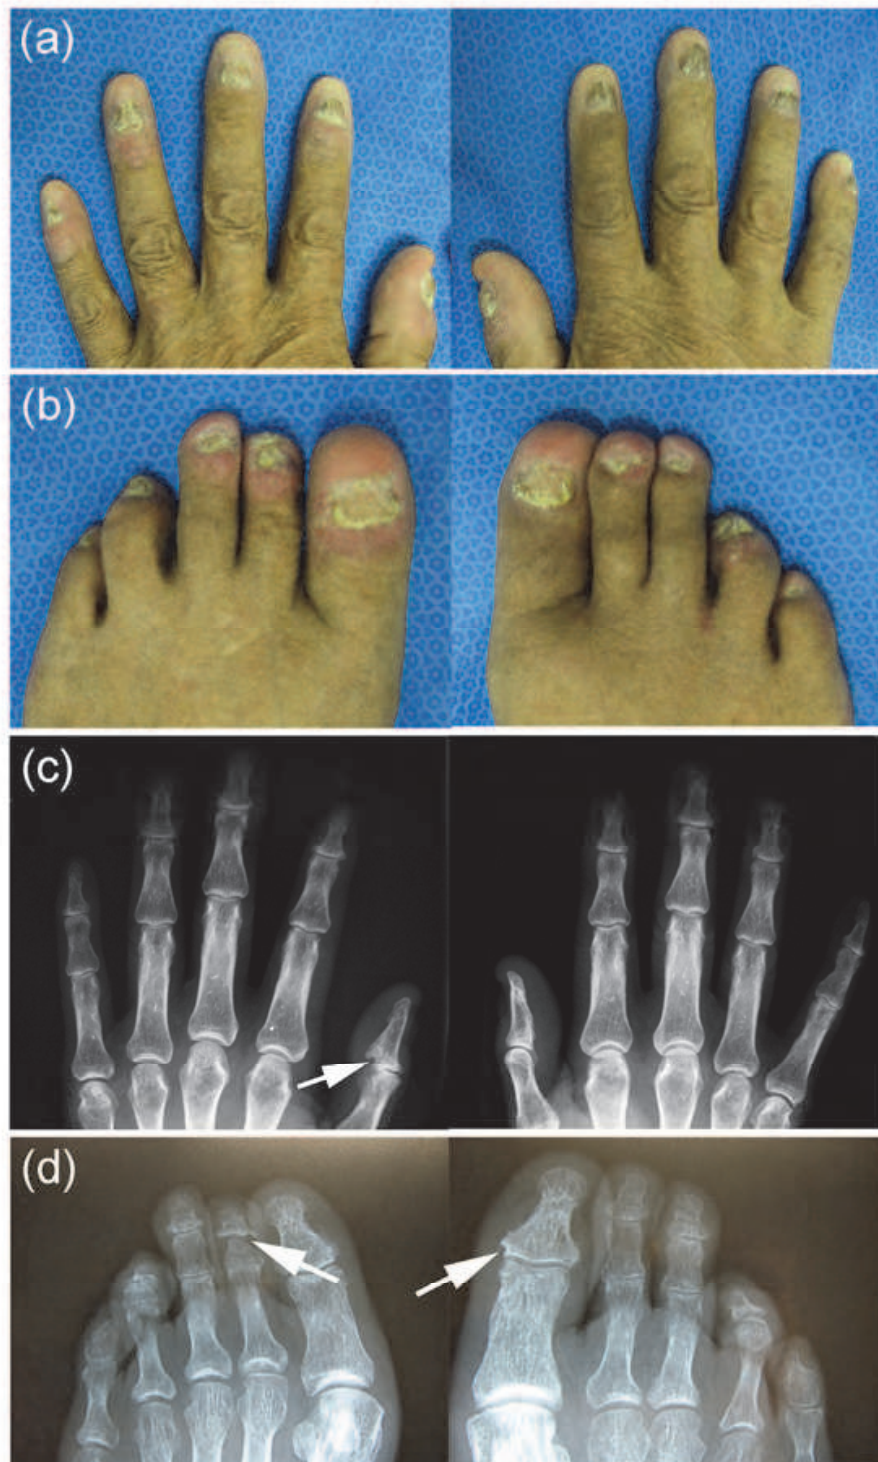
Clinical findings of fingers (a), toes (b), and radiographs of bilateral fingers (c) and toes (d) in a patient with SAPHO syndrome accompanied by acrodermatitis continua of Hallopeau. Erythema, pustules and onychodystrophy are present on all fingers and toes, which are compatible with the dermatological features of acrodermatitis continua of Hallopeau (a, b). Characteristic osteolysis of acrodermatitis continua of Hallopeau are observed in phalanges of fingers (c) and toes (d).
